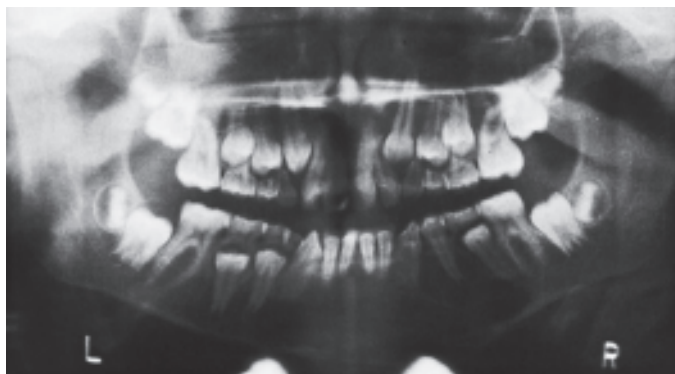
Radiographic appearance of central giant cell granuloma
